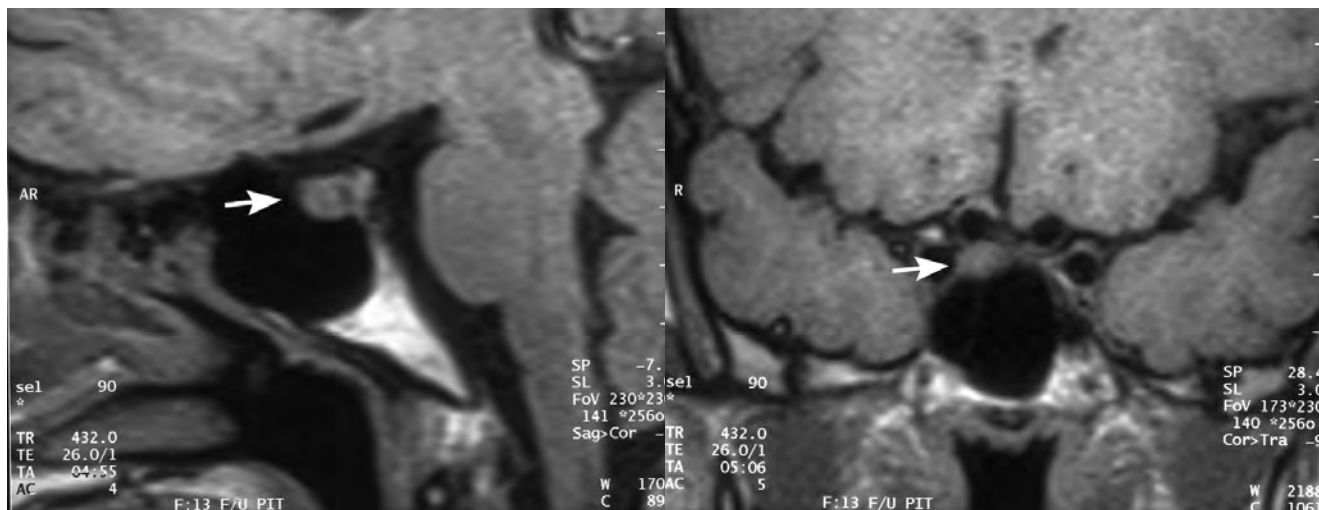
MRI Brain: Sagittal and coronal T1-weighted images showing a 6 mm pituitary microadenoma (arrow) without suprasellar extension or compression of adjacent brain parenchyma.
